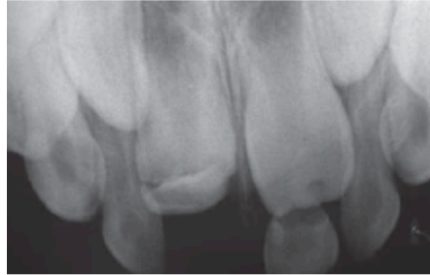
Radiographic examination 4 years after dental trauma revealed signs of alteration in the germ of the maxillary right central permanent incisor.
